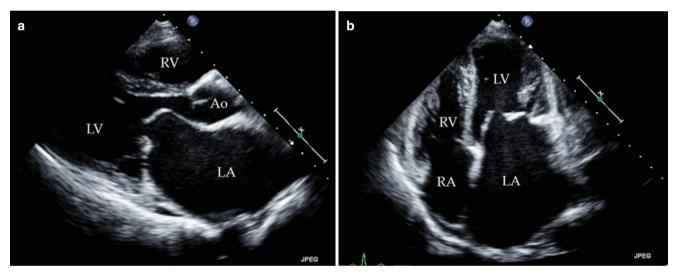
(a) Parasternal long-axis view of mitral stenosis. The left atrium (LA) is enlarged, mitral opening is limited, and "doming" of the anterior mitral leaflet is present. (b) Apical four-chamber plane in mitral
